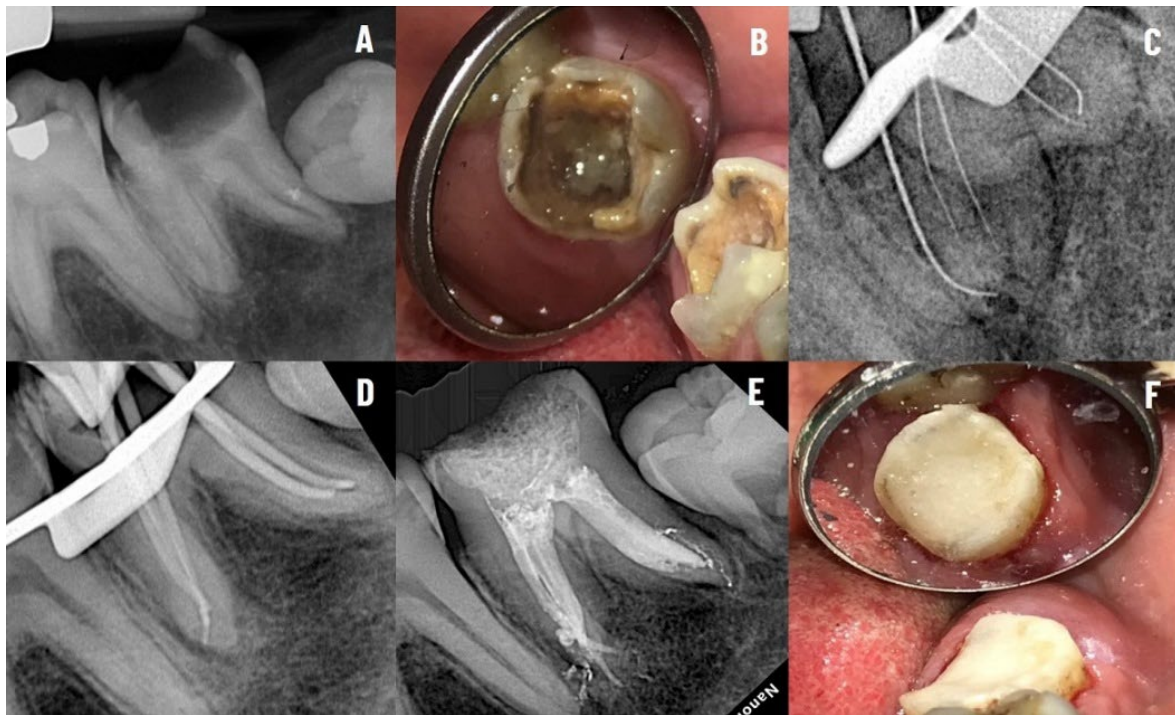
Clinical and radiographic evaluation of the instrumentation and obturation of #37 showing: A) Initial radiograph; B) Clinical view at admission; C) Radiograph with K-file confirming the root canals working length; D) Master-cone confirming radiograph; E) Post-op radiograph; and F) Clinical view after temporization
